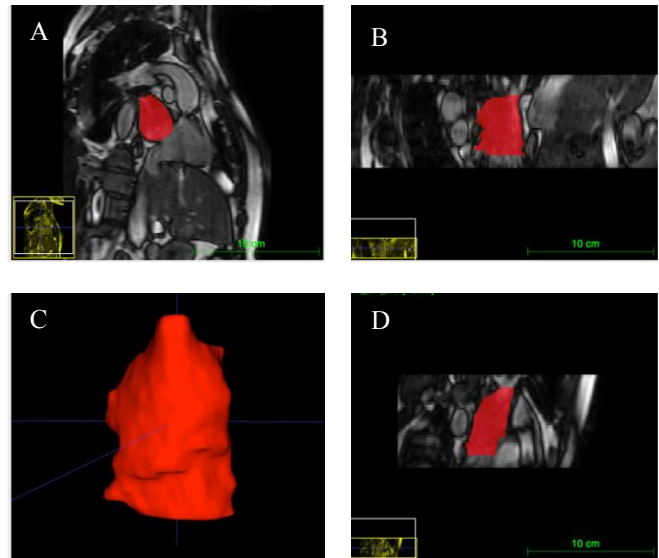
Representative CINE MRI image (reference frame). Three orthogonal views (A, B, D) are shown overlaid with the manual left atrial segmentation and its rendering for a healthy volunteer (C).
